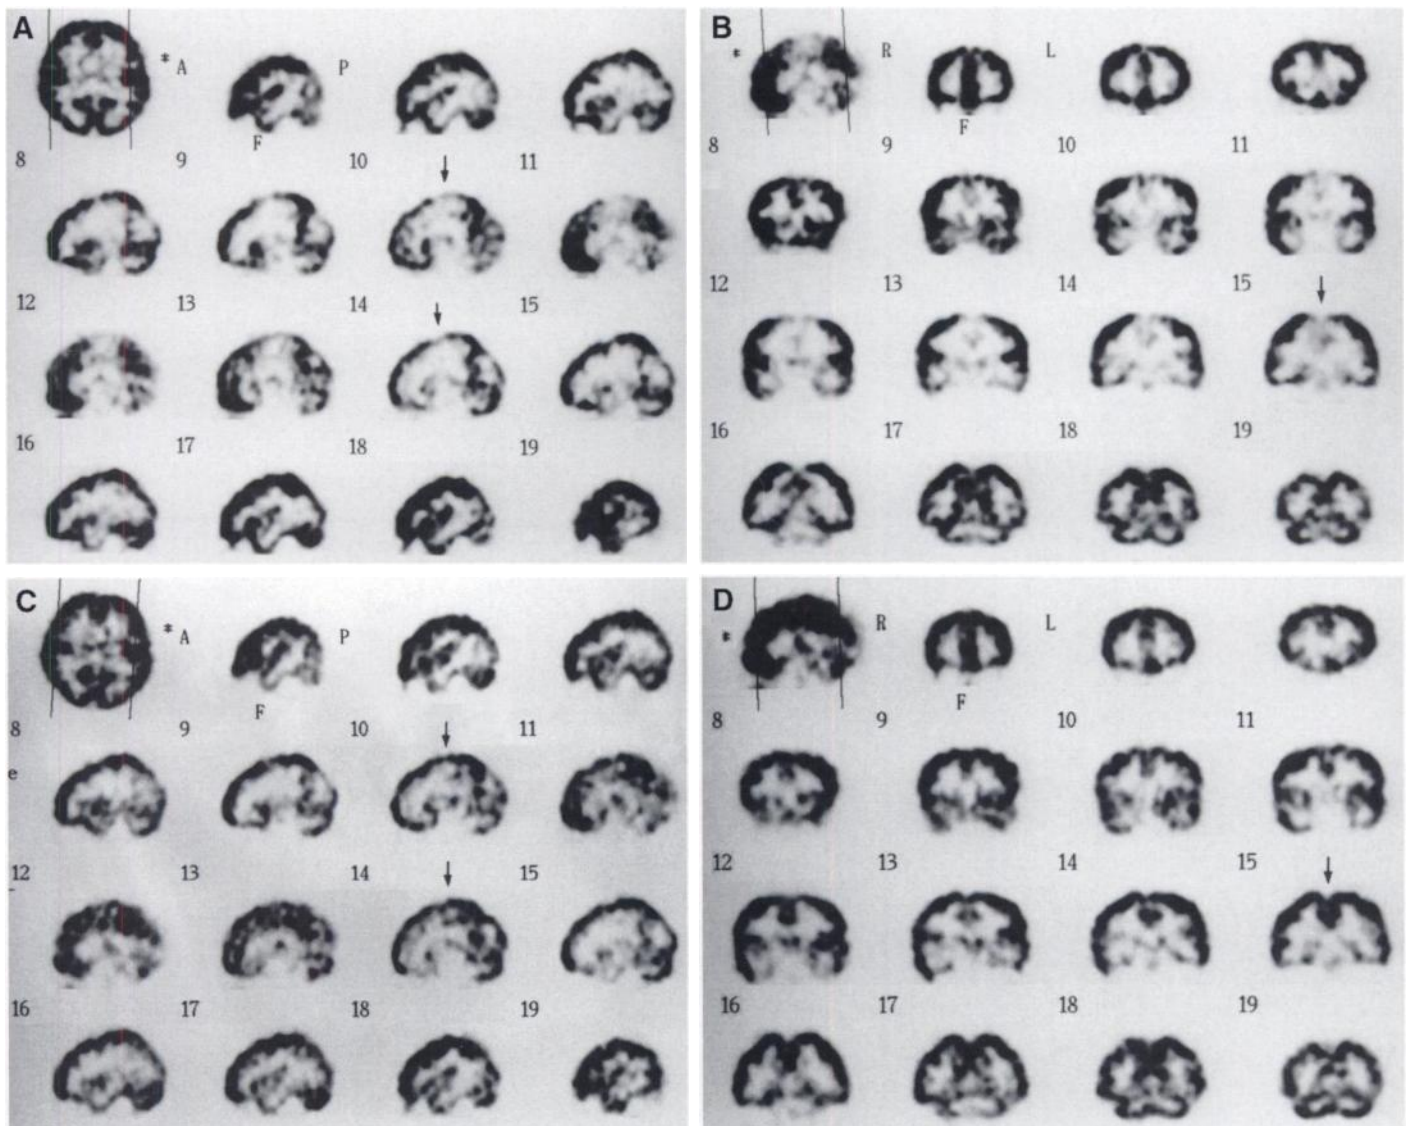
Technetium-99m-HMPAO SPECT sagittal (A) and coronal (B) images show multiple hypoperfusion areas in the brain, especially in both the high frontal lobes and cingulate gyri (arrows), before flunarizine treatment. Reperfusion in the high frontal areas and cingulate gyri (arrows) were detected after flunarizine treatment (C,D).
